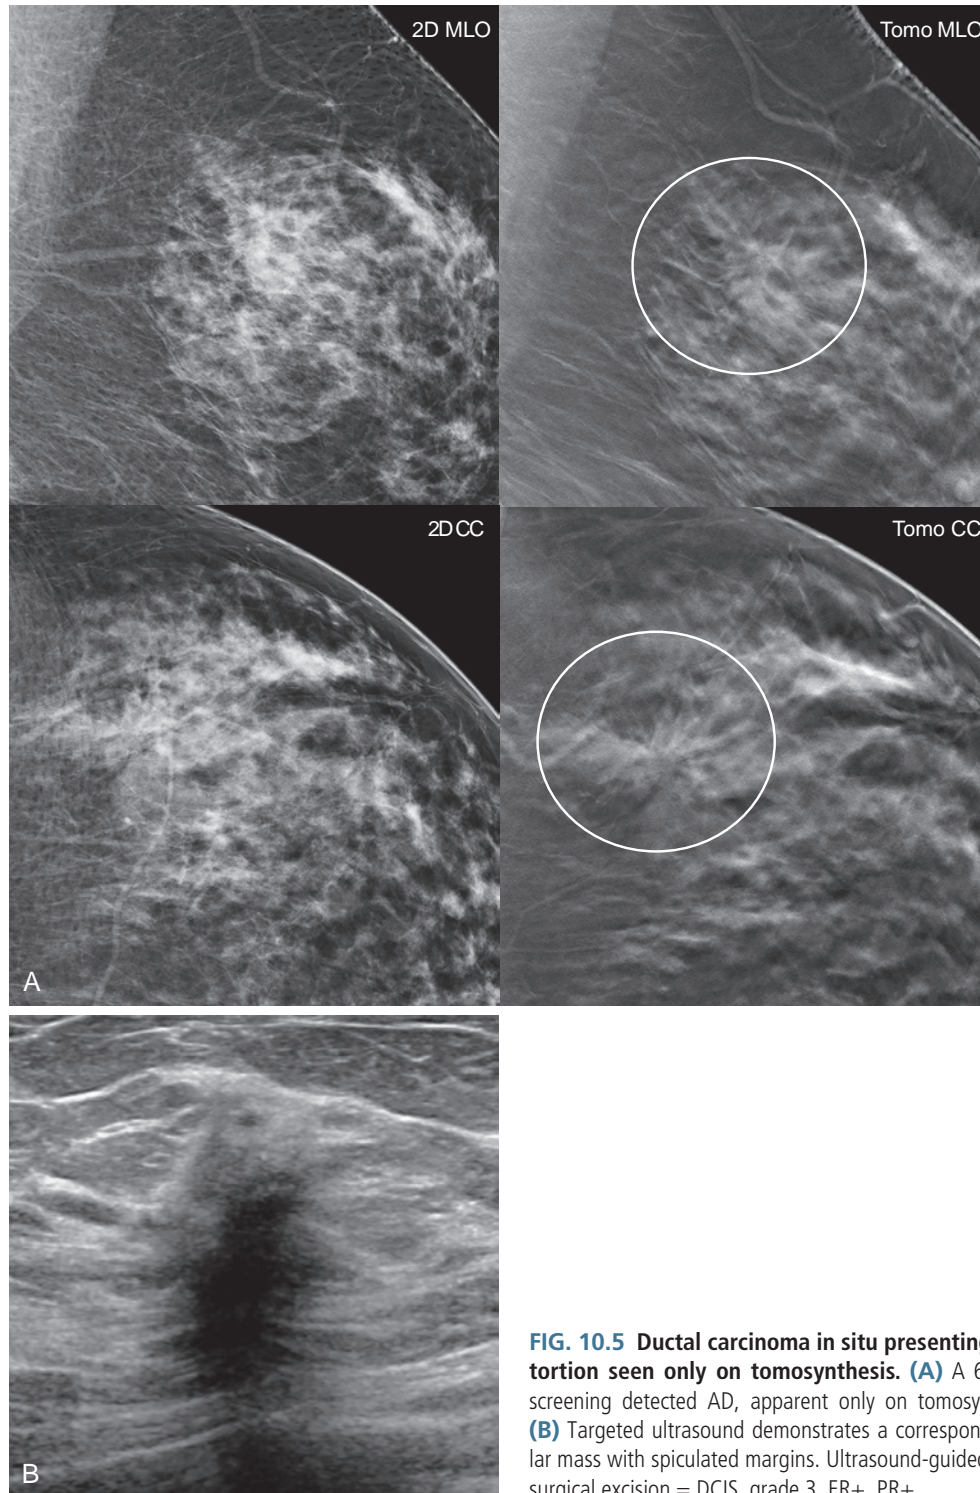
Ductal carcinoma in situ presenting as architectural distortion seen only on tomosynthesis. (A) A 60-year-old woman with screening detected AD, apparent only on tomosynthesis images (*circles*). (B) Targeted ultrasound demonstrates a corresponding hypoechoic, irregular mass with spiculated margins. Ultrasound-guided core needle biopsy and surgical excision = DCIS, grade 3, ER+, PR+.
